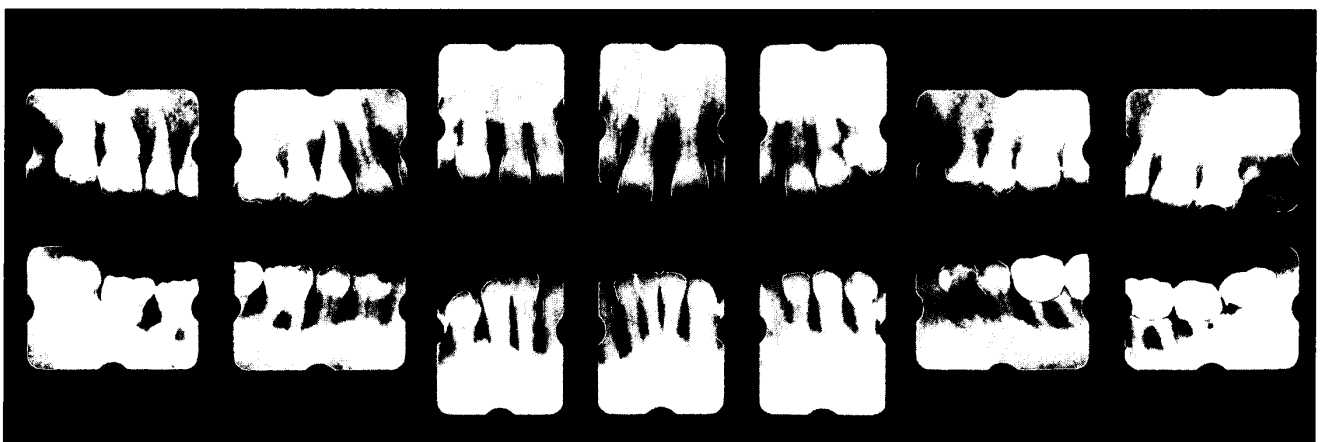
X-ray findings at first medical examination.
